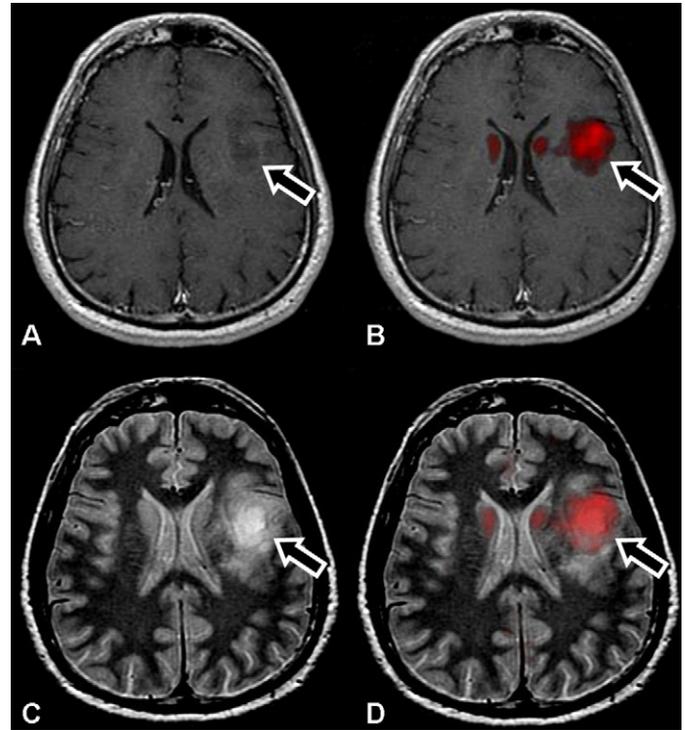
Non-enhancing tumor (grade II oligodendroglioma) on contrast-enhanced T1W MRI (A, arrow) shows high  $^{18}\text{F}$ -FDOPA activity as seen on the  $^{18}\text{F}$ -FDOPA PET-MRI fusion image (B, arrow). T2W signal abnormality (C, arrow) corresponds well with the region of elevated  $^{18}\text{F}$ -FDOPA activity (D, arrow).
